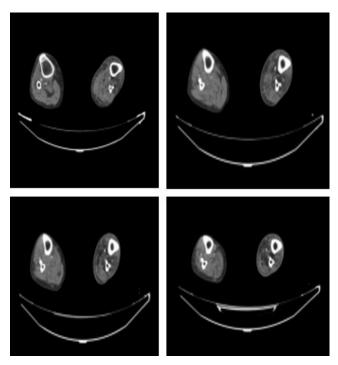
CT angiography with acute arterial occlusion
